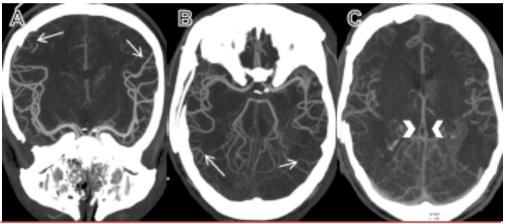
CTA targets were distal middle cerebral arteries segments (arrows in A and B) and internal cerebral veins (arrowheads in C)
